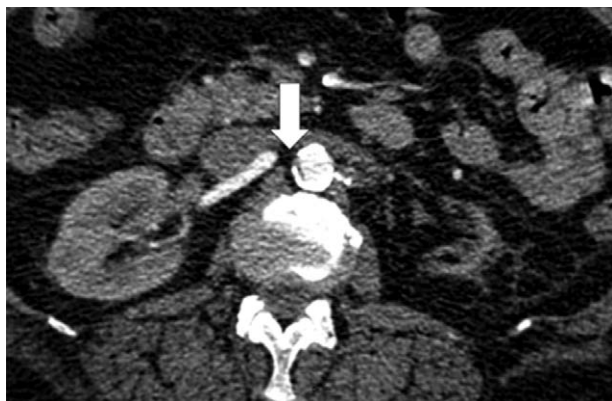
Computed tomographic renal angiography showing tight ostial right renal artery stenosis.
